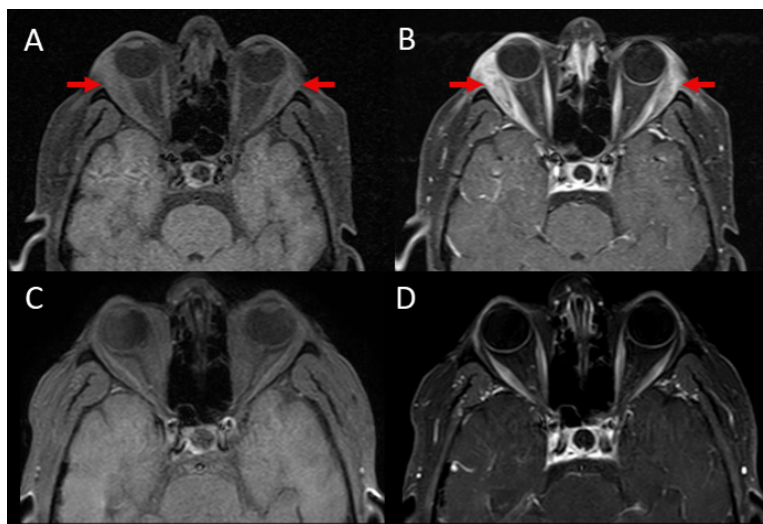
On pre-treatment magnetic resonance images, T1-weighted non-contrast images (A) demonstrated enlargement of both lacrimal glands (red arrows), while contrast-enhanced images (B) revealed contrast enhancement of the lacrimal glands. On the post-treatment T1-weighted images (non-contrast, C; contrast-enhanced, D), regression was observed.
